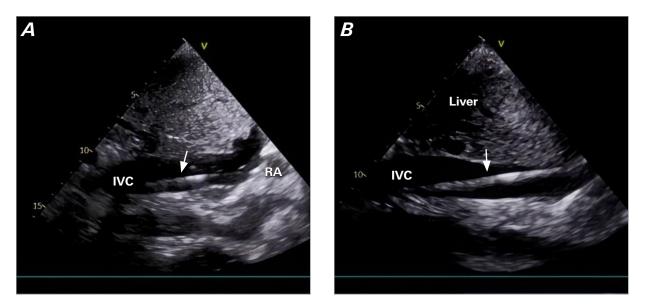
Transhepatic view during venous cannula extracorporeal membrane oxygenation cannulation. The IVC is visualized in transhepatic view. The ultrasonographic image shows A) wire (arrow) placement in the IVC toward the right atrium, not the hepatic vein (asterisk) and B) the venous cannula (arrow) positioned correctly in the IVC.
